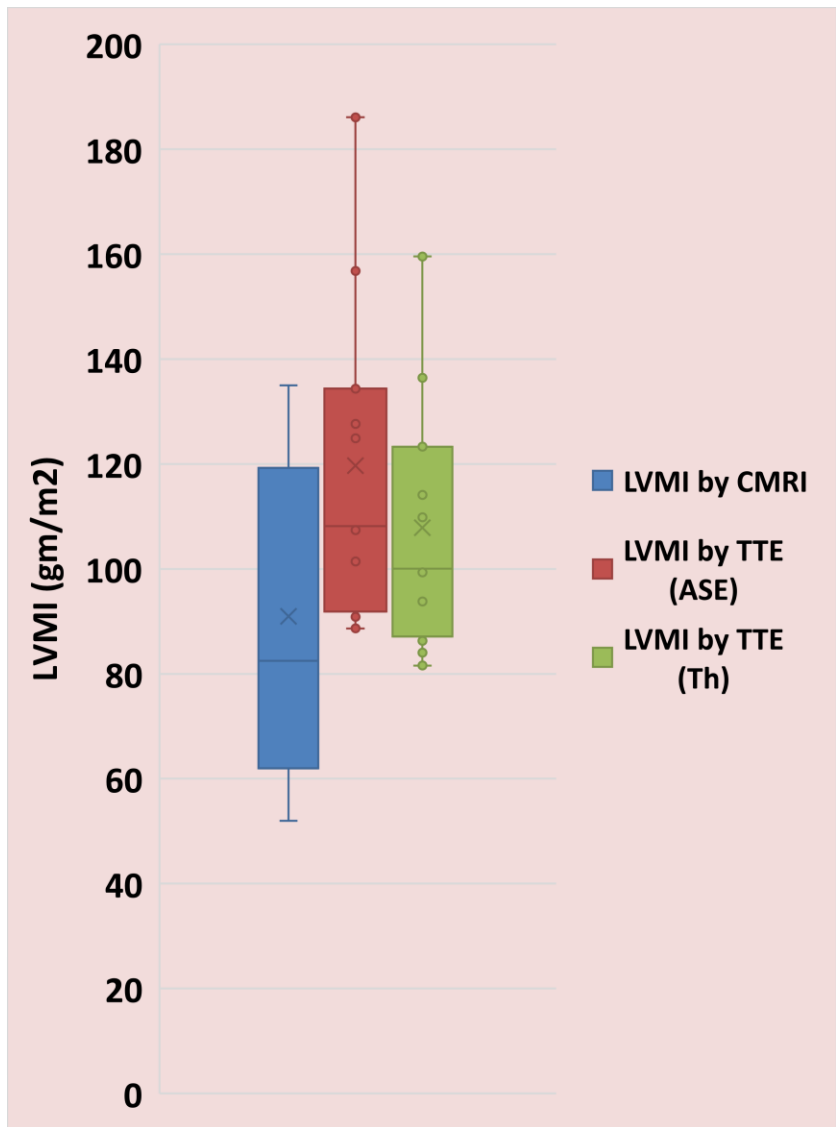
Comparison of left ventricular mass index (LVMI) by transthoracic echocardiography (TTE) ASE and Th formula, and cardiac MRI.
